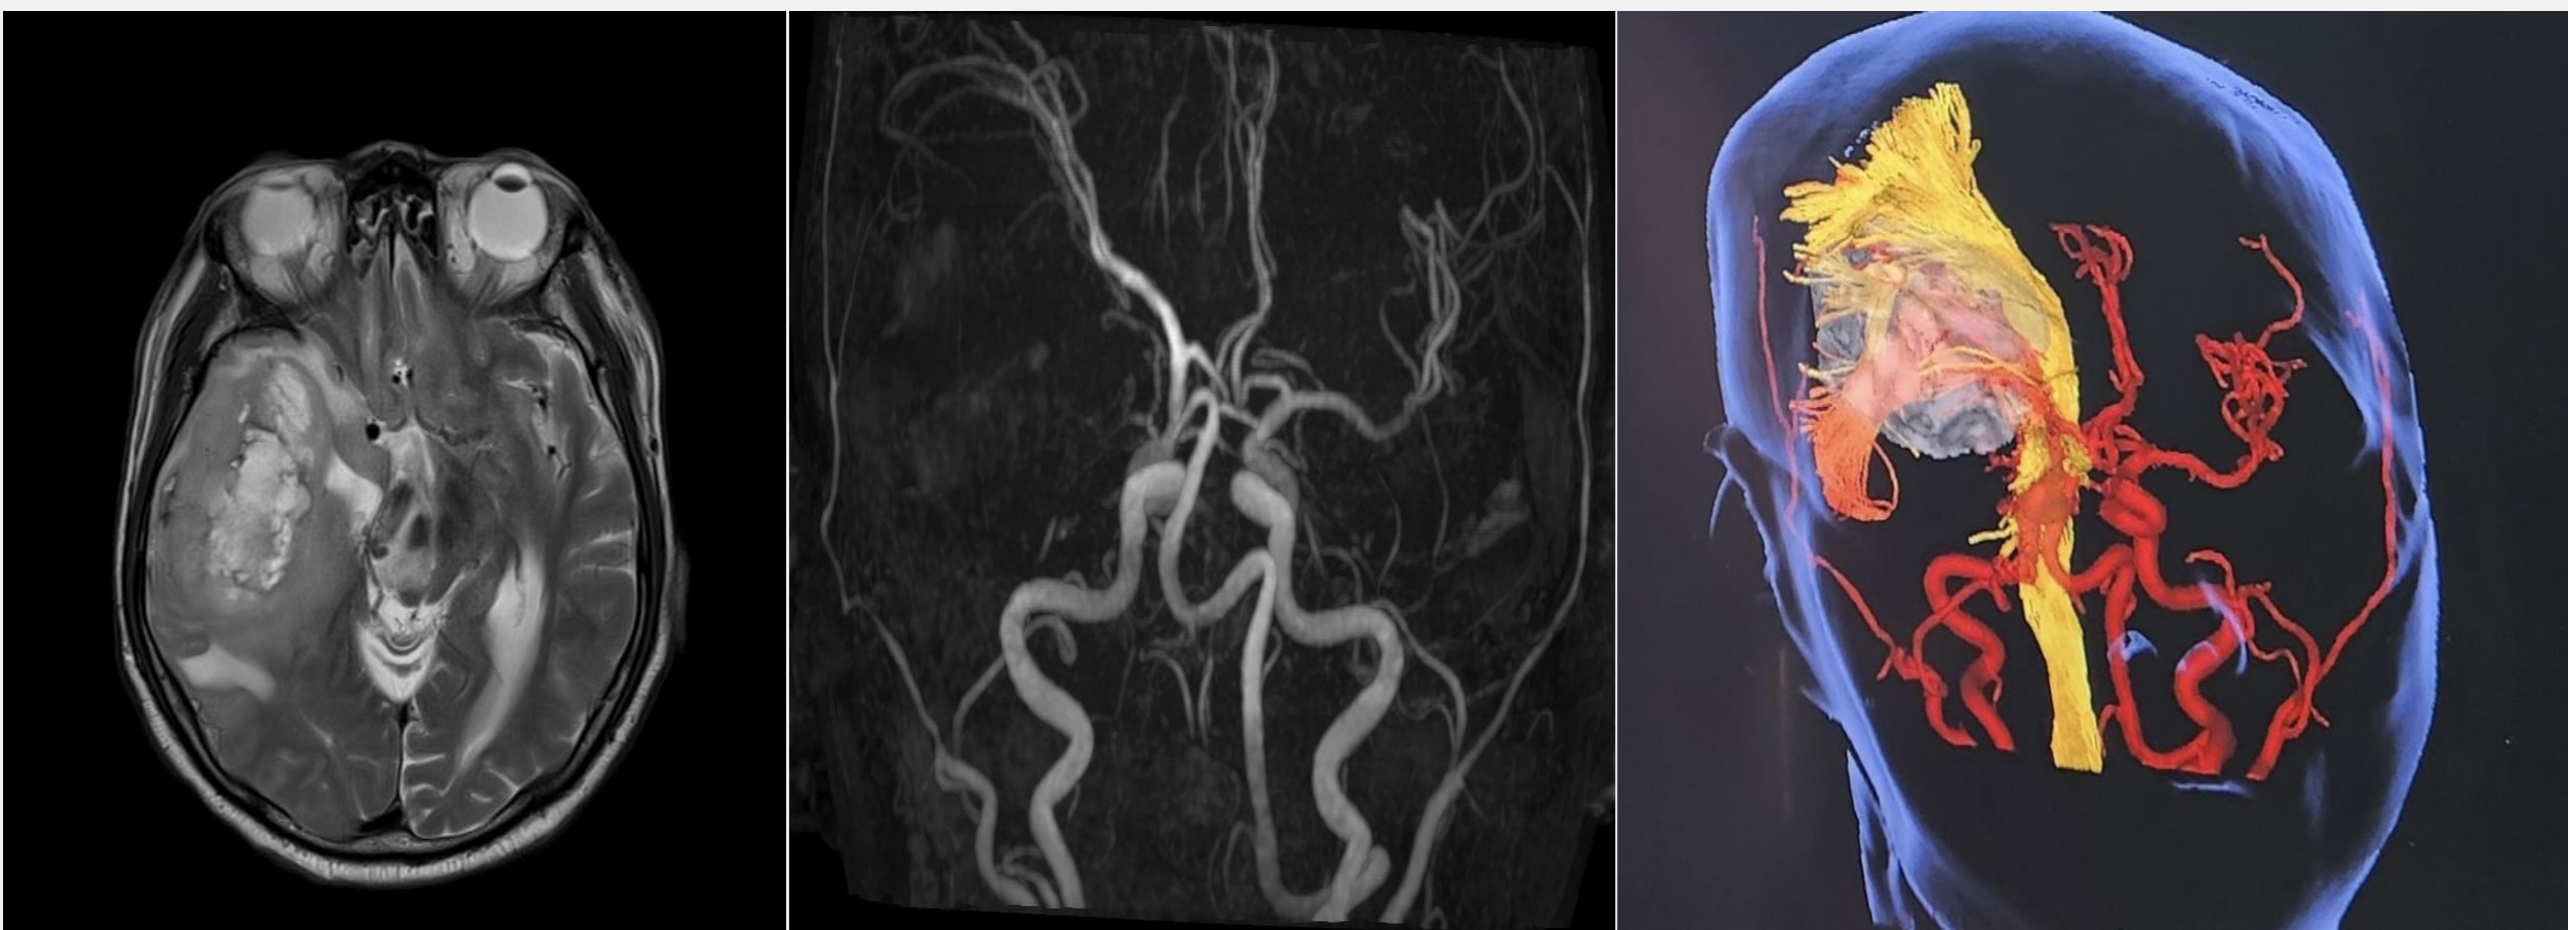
MRI, MRA and tractography of brain tumor
